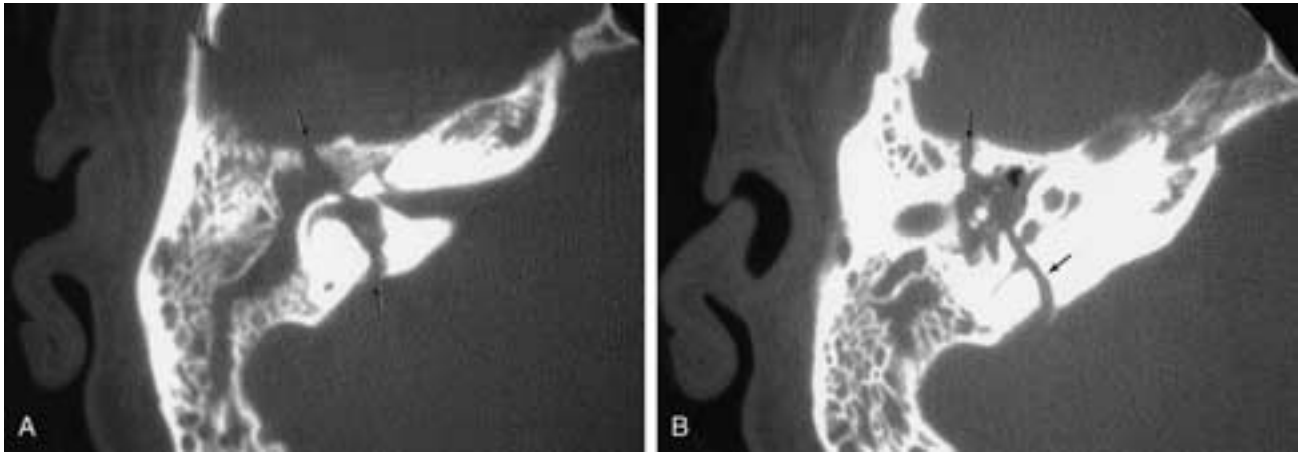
Transverse fracture, lateral subtype. A, Axial CT image, right ear. Fracture (*arrows*) begins at the posterior petrous surface in the vicinity of the vestibular aqueduct and disrupts the anterior portion of the tegmen tympani, as well as the squamous portion of the petrous bone. B, Axial CT image, right ear, more inferior, also reveals disruption of the promontory fracture (*arrows*). Note the diffuse hematotympanum.
